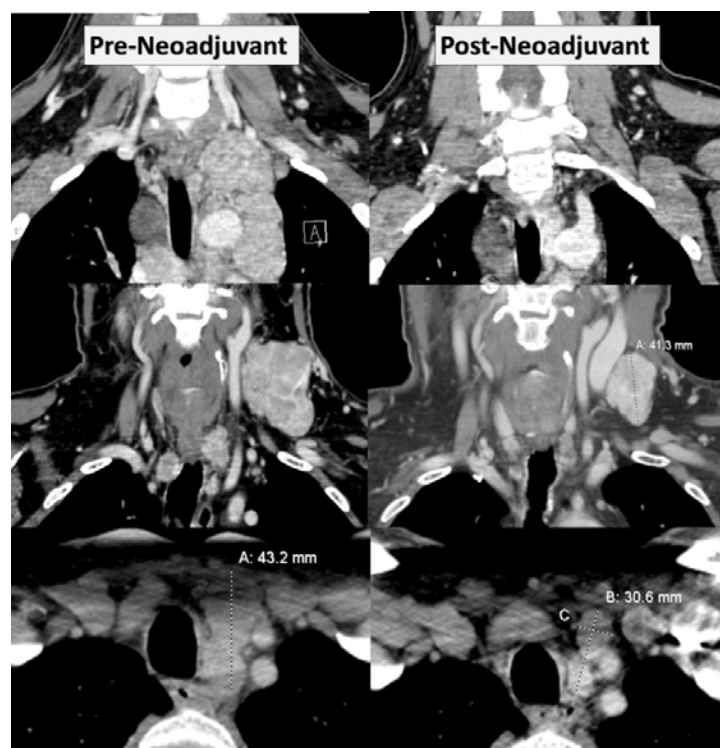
CT Neck Pre- and Post-Neoadjuvant Selective RET Inhibitor
